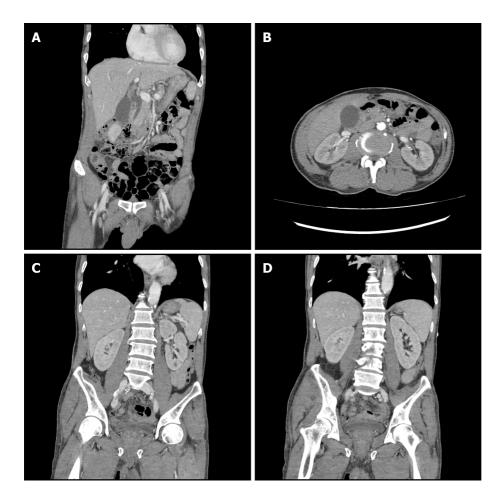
Computed tomography of abdomen and pelvis at the emergency department. A: The common bile duct was mildly dilated, but it was considered as a senile change without any obvious obstructive lesion; B: Both renal parenchymal enhancements were decreased; C: Both kidney sizes and shapes were relatively normal.
